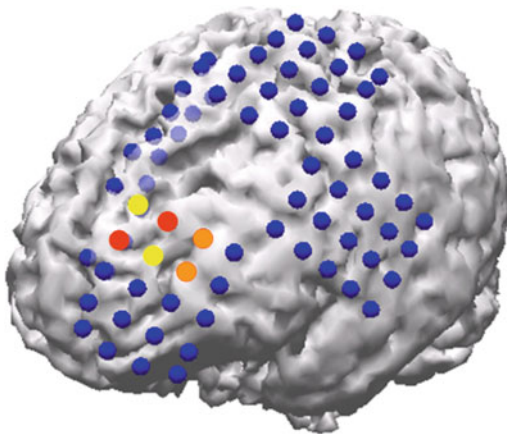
3D reconstruction of the brain coregistered with the postoperative CT to localize the electrodes in relationship to gyral anatomy
